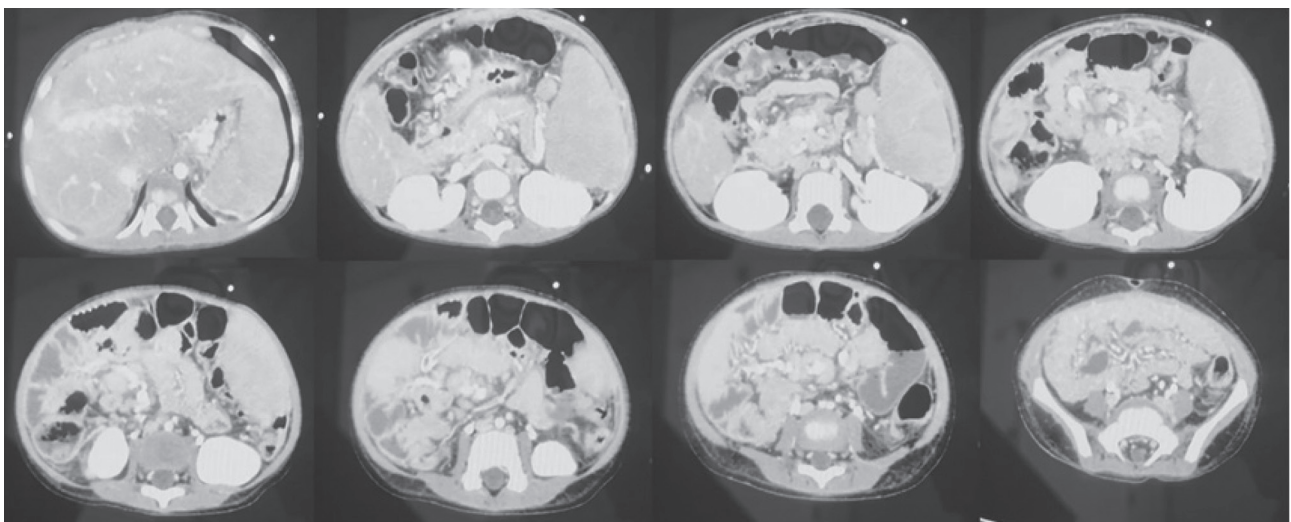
Computed tomography (CT) angiography showed severe stenosis of the main portal.
